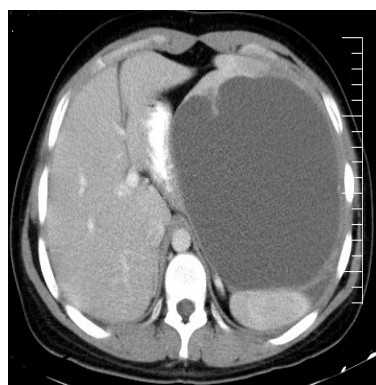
Computed tomogram shows a large cystic lesion in the spleen (axial view)
